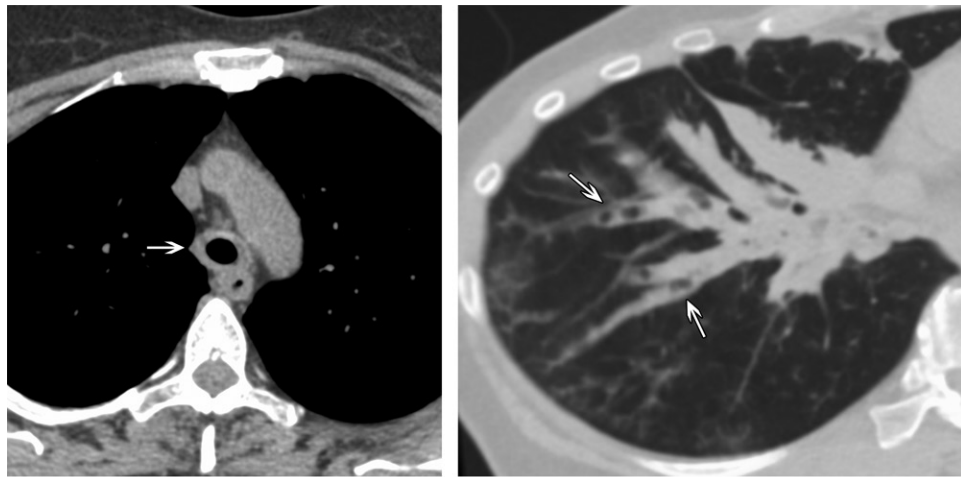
Abnormalities of the large and medium airways in a 49-year-old woman with ulcerative colitis. (a) Axial CT image shows circumferential tracheal wall thickening (arrow). (b) Oblique volume-rendered CT image shows bronchiectasis and the debris material-filled airways of the right lower lobe (arrows), as well as right middle lobe atelectasis. Similar but less severe airway abnormalities were present in the lingula (not shown). (Case courtesy of Jonathan H. Chung, MD, University of Chicago, Chicago Ill.)
